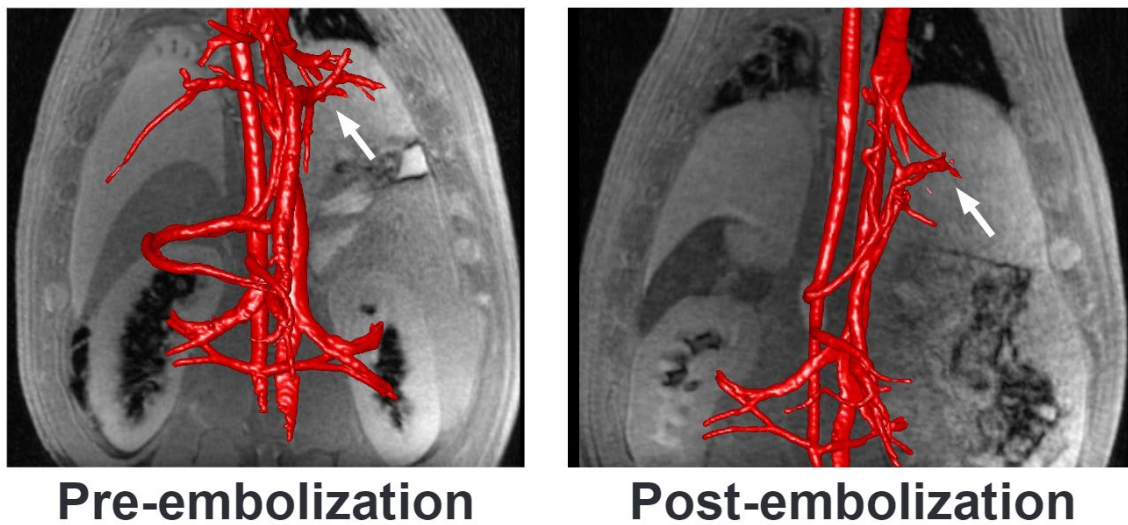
Pre- and post-embolization MRI images of the hepatic and splenic vasculature
